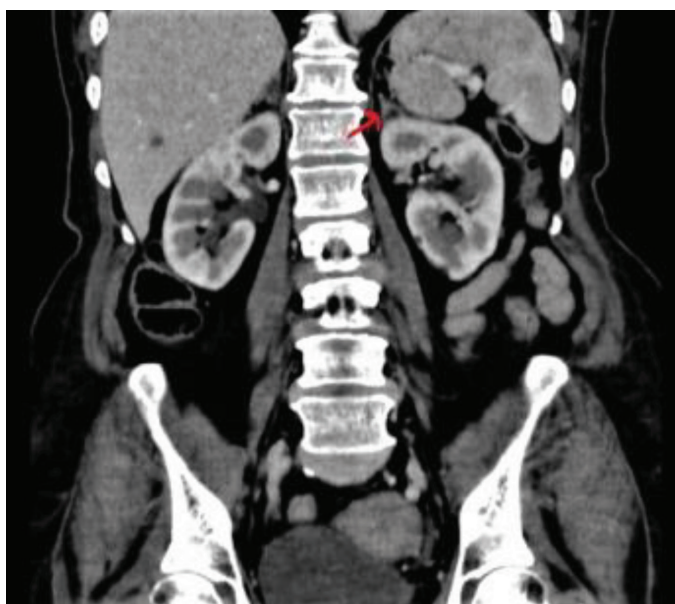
Contrast-enhanced abdominal computed tomography shows a 32x14 mm heterogeneously enhancing nodular lesion with exophytic extension in the upper pole of the left kidney (RCC)
